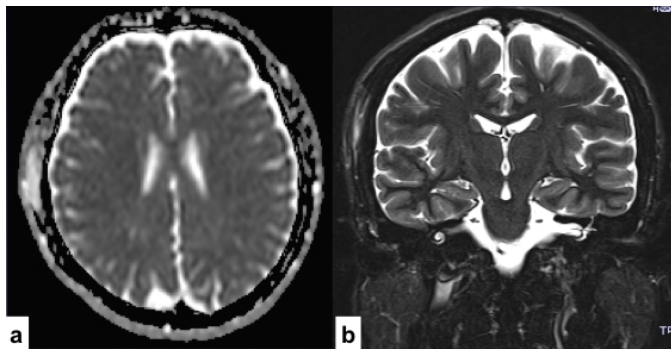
Brain MRI of a high school baseball player who was hit by a pitched ball showing subcutaneous hematoma in the right temporal region.
